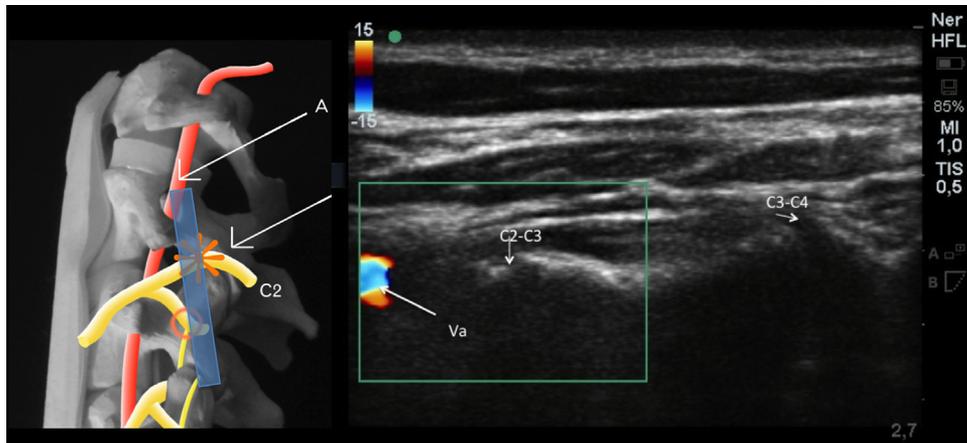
Probe placement (blue bar) C2-C3 and C3-C4 articulations in the center of the ultrasound picture, deeper pulsation of the vertebral artery can be seen. The use of Doppler sonography may facilitate the identification of this important landmark. Va, vertebral artery; C2-C3, zygoapophyseal joint C2-C3; C3-C4, zygapophysial joint C3-C4. (Color version of figure is available online.)
